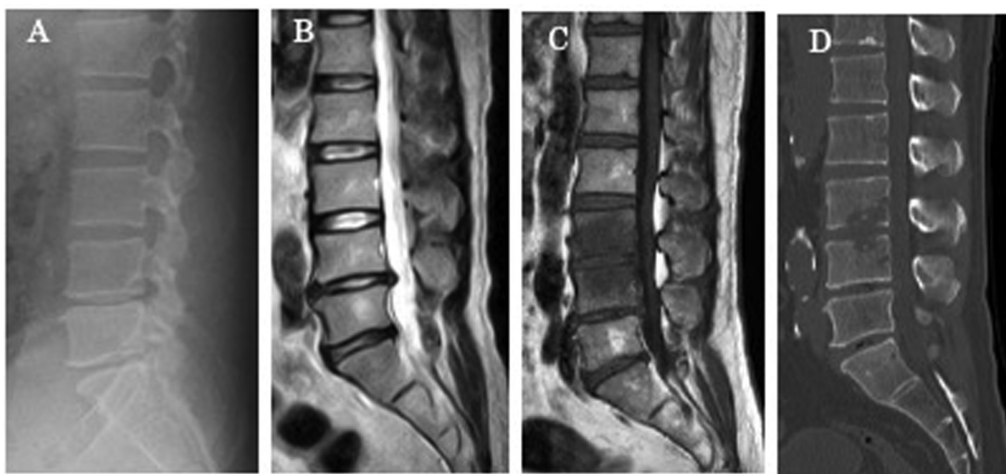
Radiological findings in a case of acute type pyogenic osteomyelitis in which neither fever nor abnormal radiological findings were noted at symptom onset. (A, B) Sagittal T2-weighted magnetic resonance image (MRI) and lumbar X-ray at onset demonstrating no abnormal findings except for mild L4/5 disc herniation. (C, D) When the patient visited our emergency department because of a fever of 39°C 3 weeks after symptom onset, T1-weighted sagittal MRI (C) demonstrated low-intensity signals in the L3/4 vertebral bodies, and computed tomography revealed bone erosion of the L3/4 intervertebral endplate (D).
